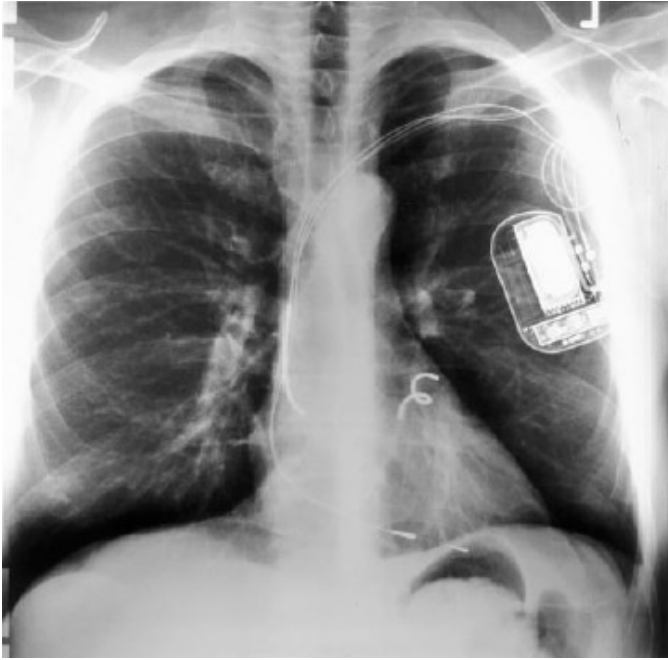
Chest radiograph of a patient with an implanted atrioverter with leads in the right atrium, the coronary sinus, and the apex of the right ventricle. The right atrial and coronary sinus leads are used for arrhythmia recognition and defibrillation. The right ventricular lead is used for shock synchronisation and, if needed, ventricular pacing
